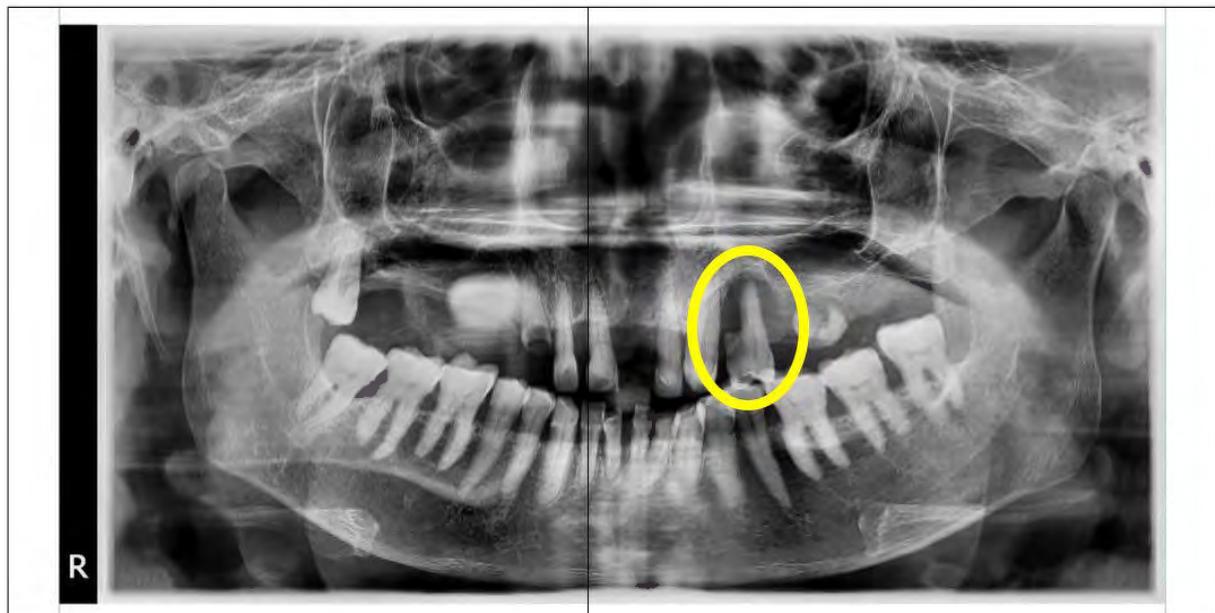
Panoramic radiograph showing radiolucent area at the apex of tooth 25, the yellow marking
